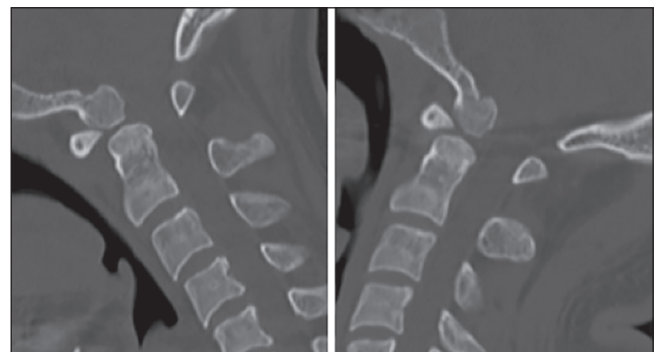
Sagittal reconstruction computed tomography showing an osseous continuity between occiput and an ossicle
